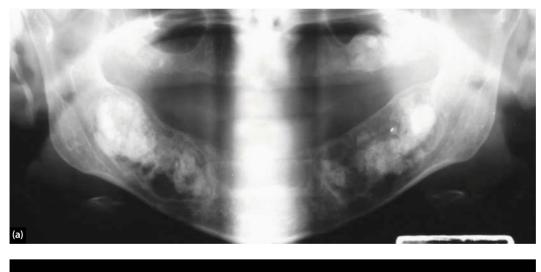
(a) Radiological appearances of florid cemento-osseous dysplasia and (b) periapical cementoosseous dysplasia (b).
